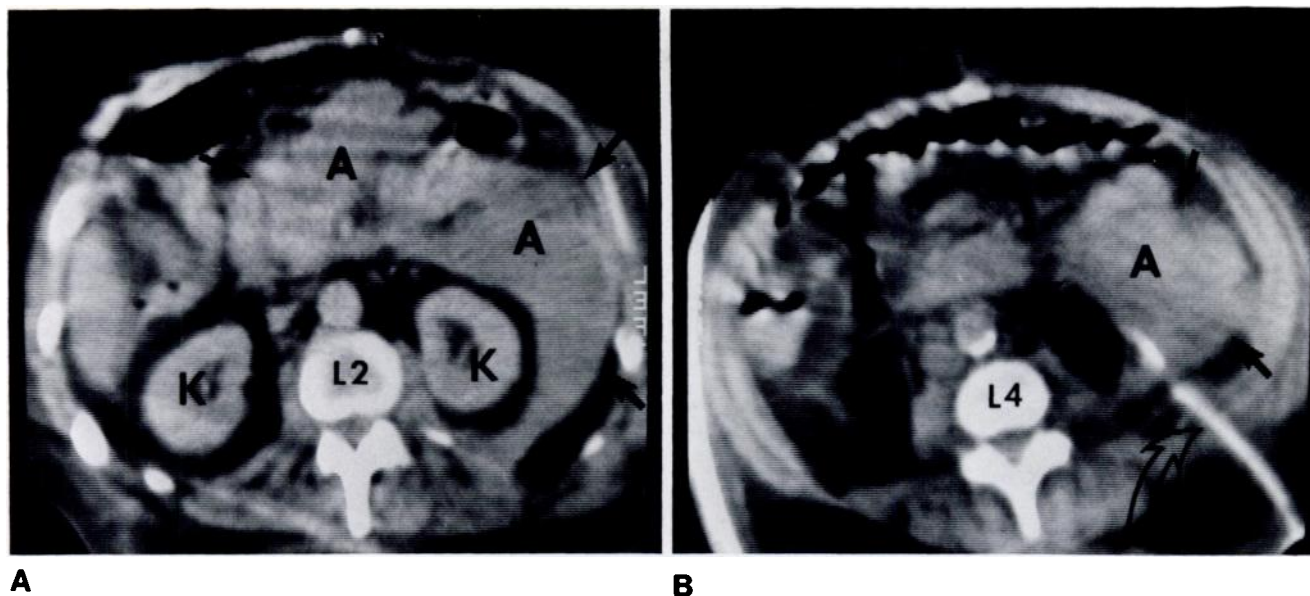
Case 4. A, CT scan of upper abdomen. Large septic phlegmon (A) involves anterior pararenal space (*arrows*) and extends posterolateral to left kidney. K = kidney, L2 = second lumbar vertebral body. B, CT scan of midabdomen. One of three 16 French trocar catheters (*open arrow*) draining lateral caudad extent of anterior pararenal space (*arrows*). L4 = fourth lumbar vertebral body.
